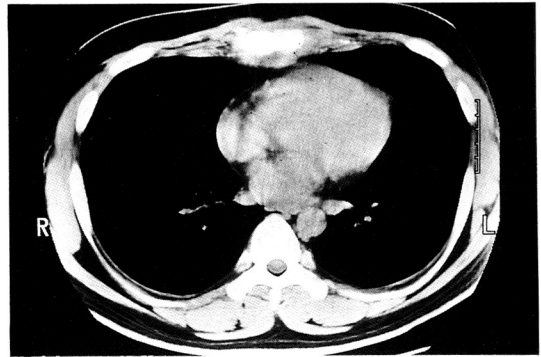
CT scan of the chest reveals irregular cortical margin with periosteal soft tissue mass in the lower portion of the sternum.
